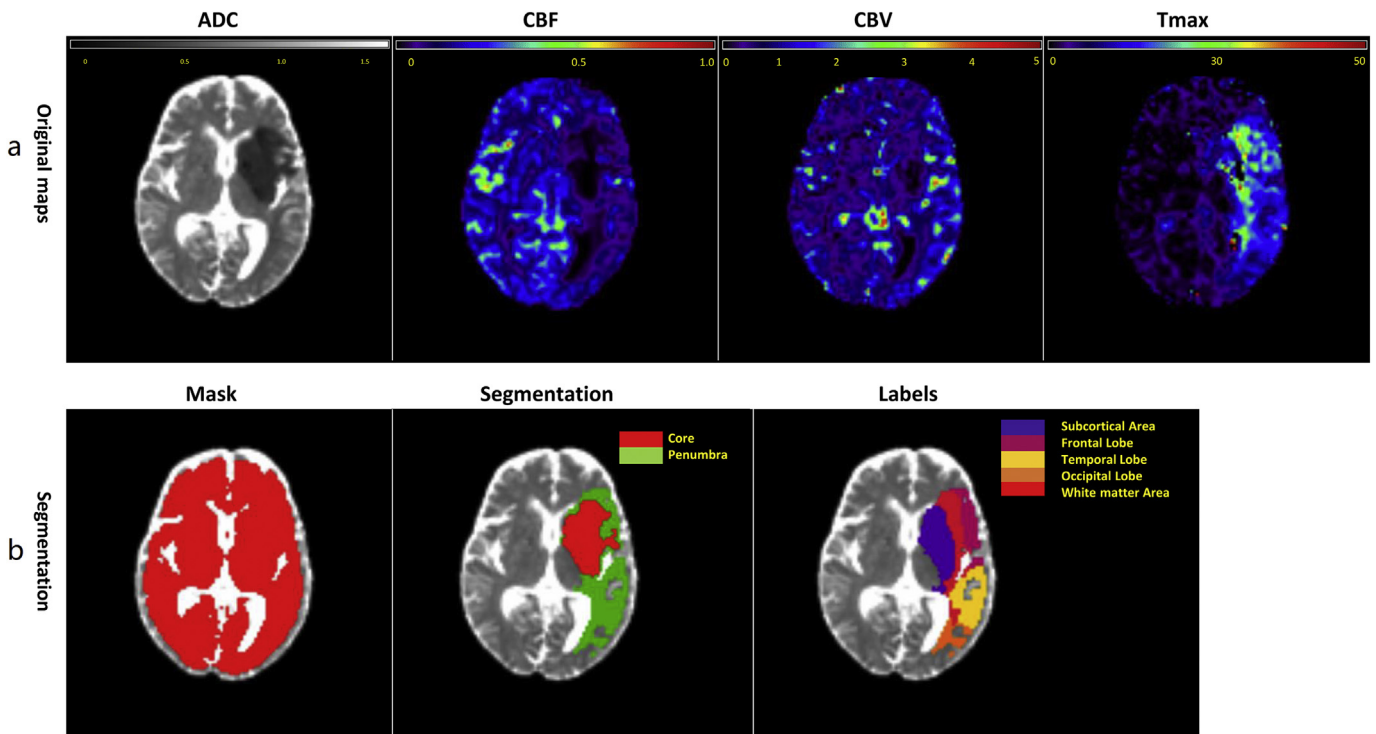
Segmentation of the penumbra and core area. (a) Original maps. ADC map, CBF map, CBV map and Tmax map; (b) mask, segmentation and labeled results. The penumbra is shown in green and the core area is shown in red. ADC = Apparent diffusion coefficient; CBF = cerebral blood flow; CBV = cerebral blood volume; DWI = diffusion-weighted imaging; PWI = perfusion-weighted imaging.
